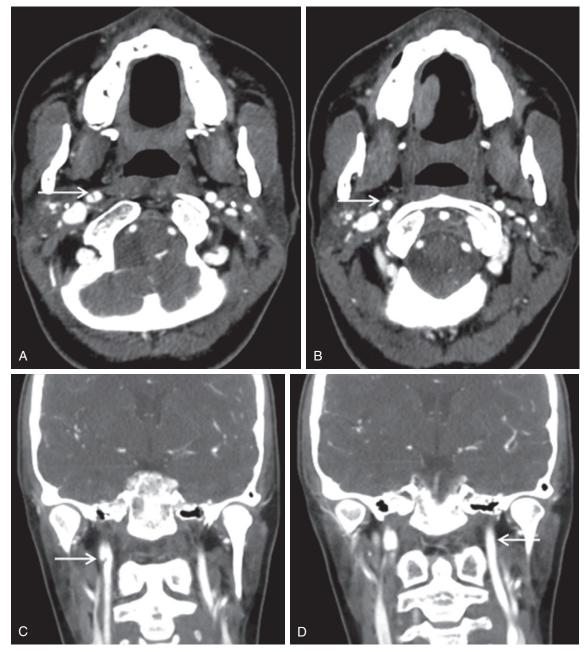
Patient presenting with left upper extremity weakness, left facial droop, and difficulty speaking. A, Axial CT source image from computed tomography angiography (CTA); *arrow* points to flap/dissection *(thin gray line)* in the lumen of the right internal carotid artery. B, Axial image just below the dissection shows a relatively narrow caliber of the right internal carotid artery *(arrow)* when compared with the left internal carotid artery. C, Coronal reconstruction of CTA delineates flap/dissection *(arrow)* in right internal carotid artery. D, Coronal reconstruction indicating normal appearance of the left internal carotid artery.
